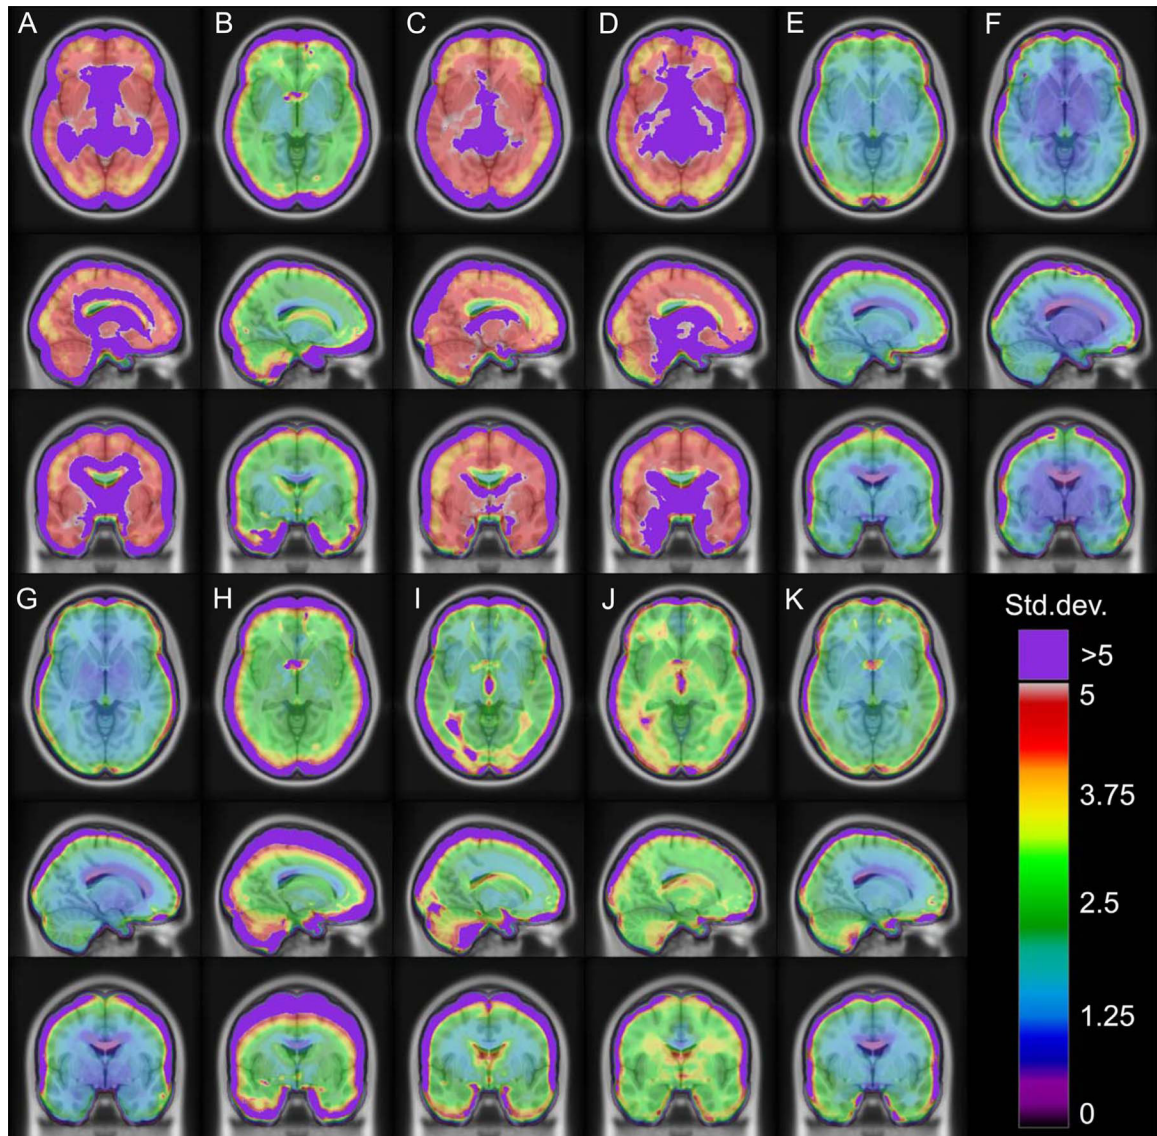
Standard deviation images across all FDG $Rel_{\%}$ images (n=201, including patients with fat/water tissue inversion) for each method: (A) Dixon, (B) UTE, (C) Segbone, (D) Ontario, (E) Boston, (F) UCL, (G) MaxProb, (H) MLAA, (I) Munich, (J) CAR-RiDR, (K) RESOLUTE.
